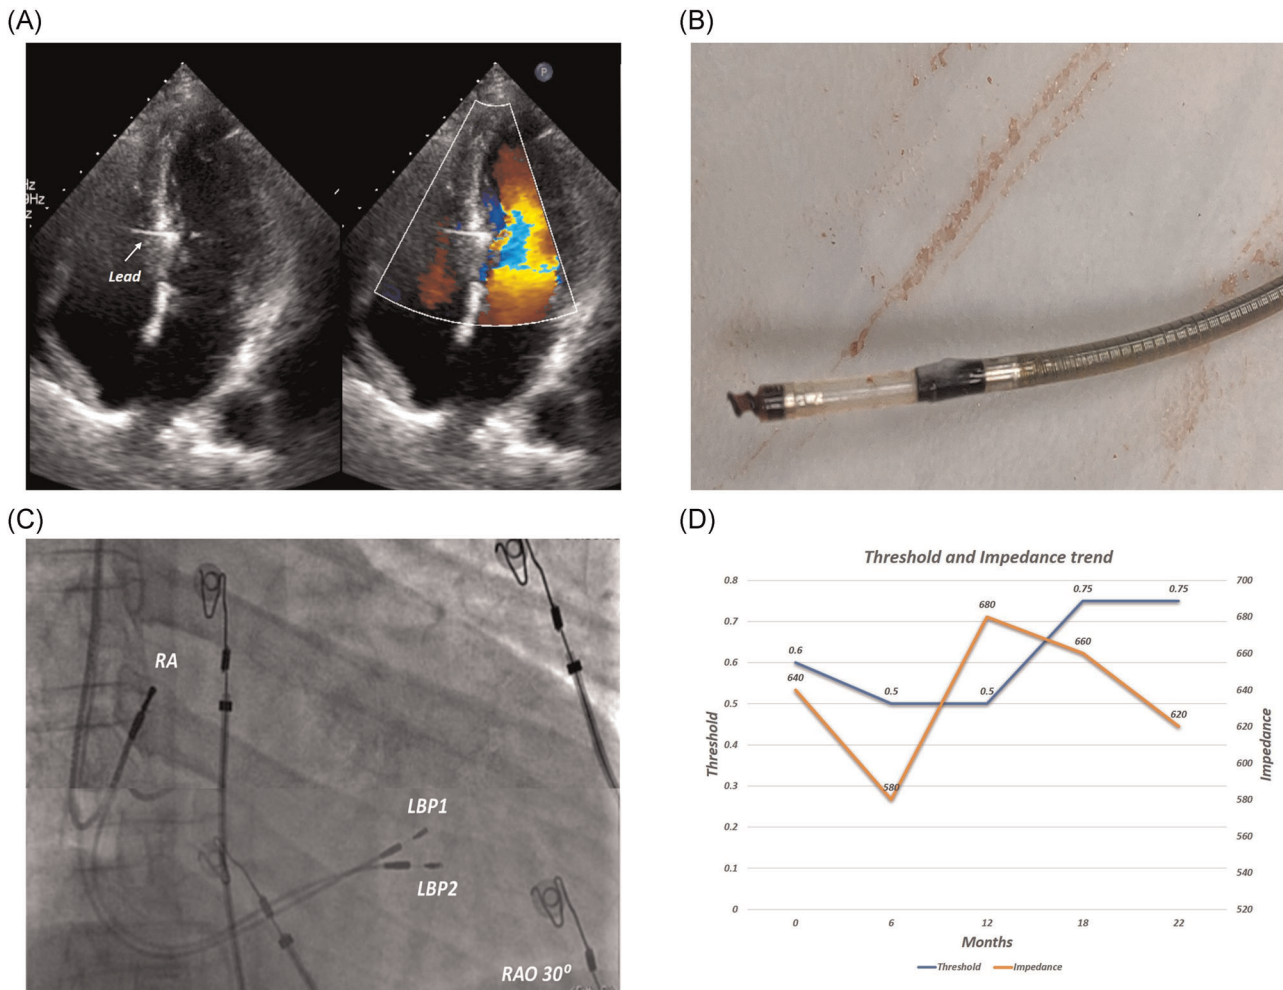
(A) Echocardiography showing the depth of the pacing lead and intact ventricular septum after repositioning. (B) Extracted lead with intact helix and ring electrode. (C) Superimposed fluoroscopy image in right anterior oblique (RAO) view showing pacing lead location during initial implantation (LBP1) and after reimplantation (LBP-2). (D) Threshold and pacing impedance trend from the time of implantation
